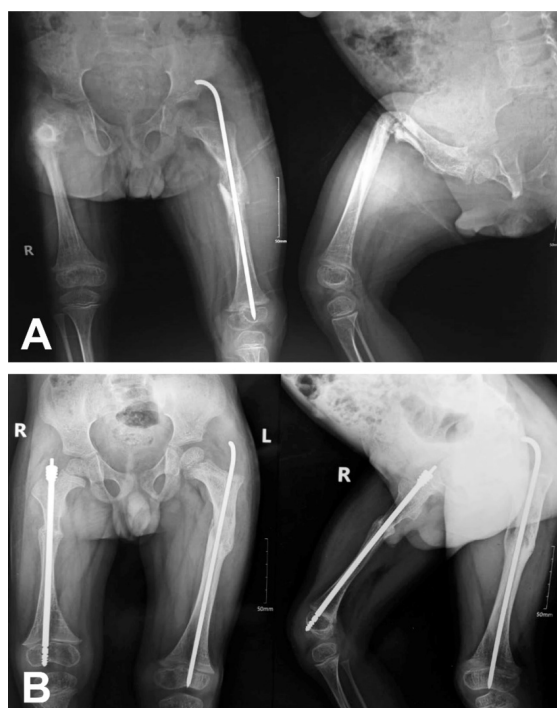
A) Pre-operative x-ray showing severe right femoral deformity in AP and lateral views, while a rush pin is inserted in the left side, B) X-ray film after spica removal and complete union with mild non-significant penetration of the male threads into the knee joint
